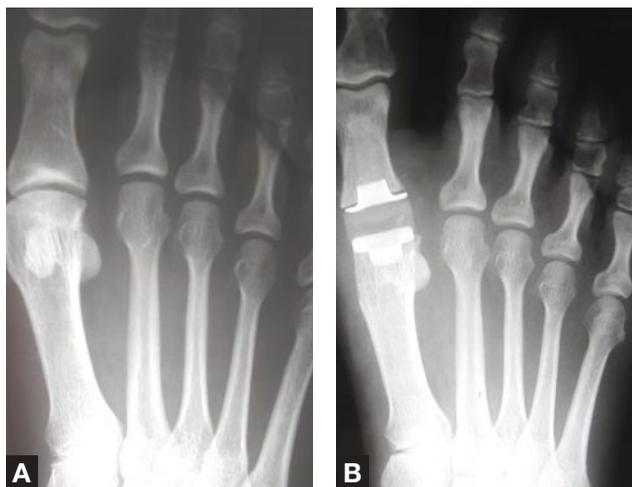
Preoperative (A) and postimplant arthroplasty (B) anteroposterior x-rays show well-seated components without gross evidence of osteolysis but with mild overlengthening of the hallux.
